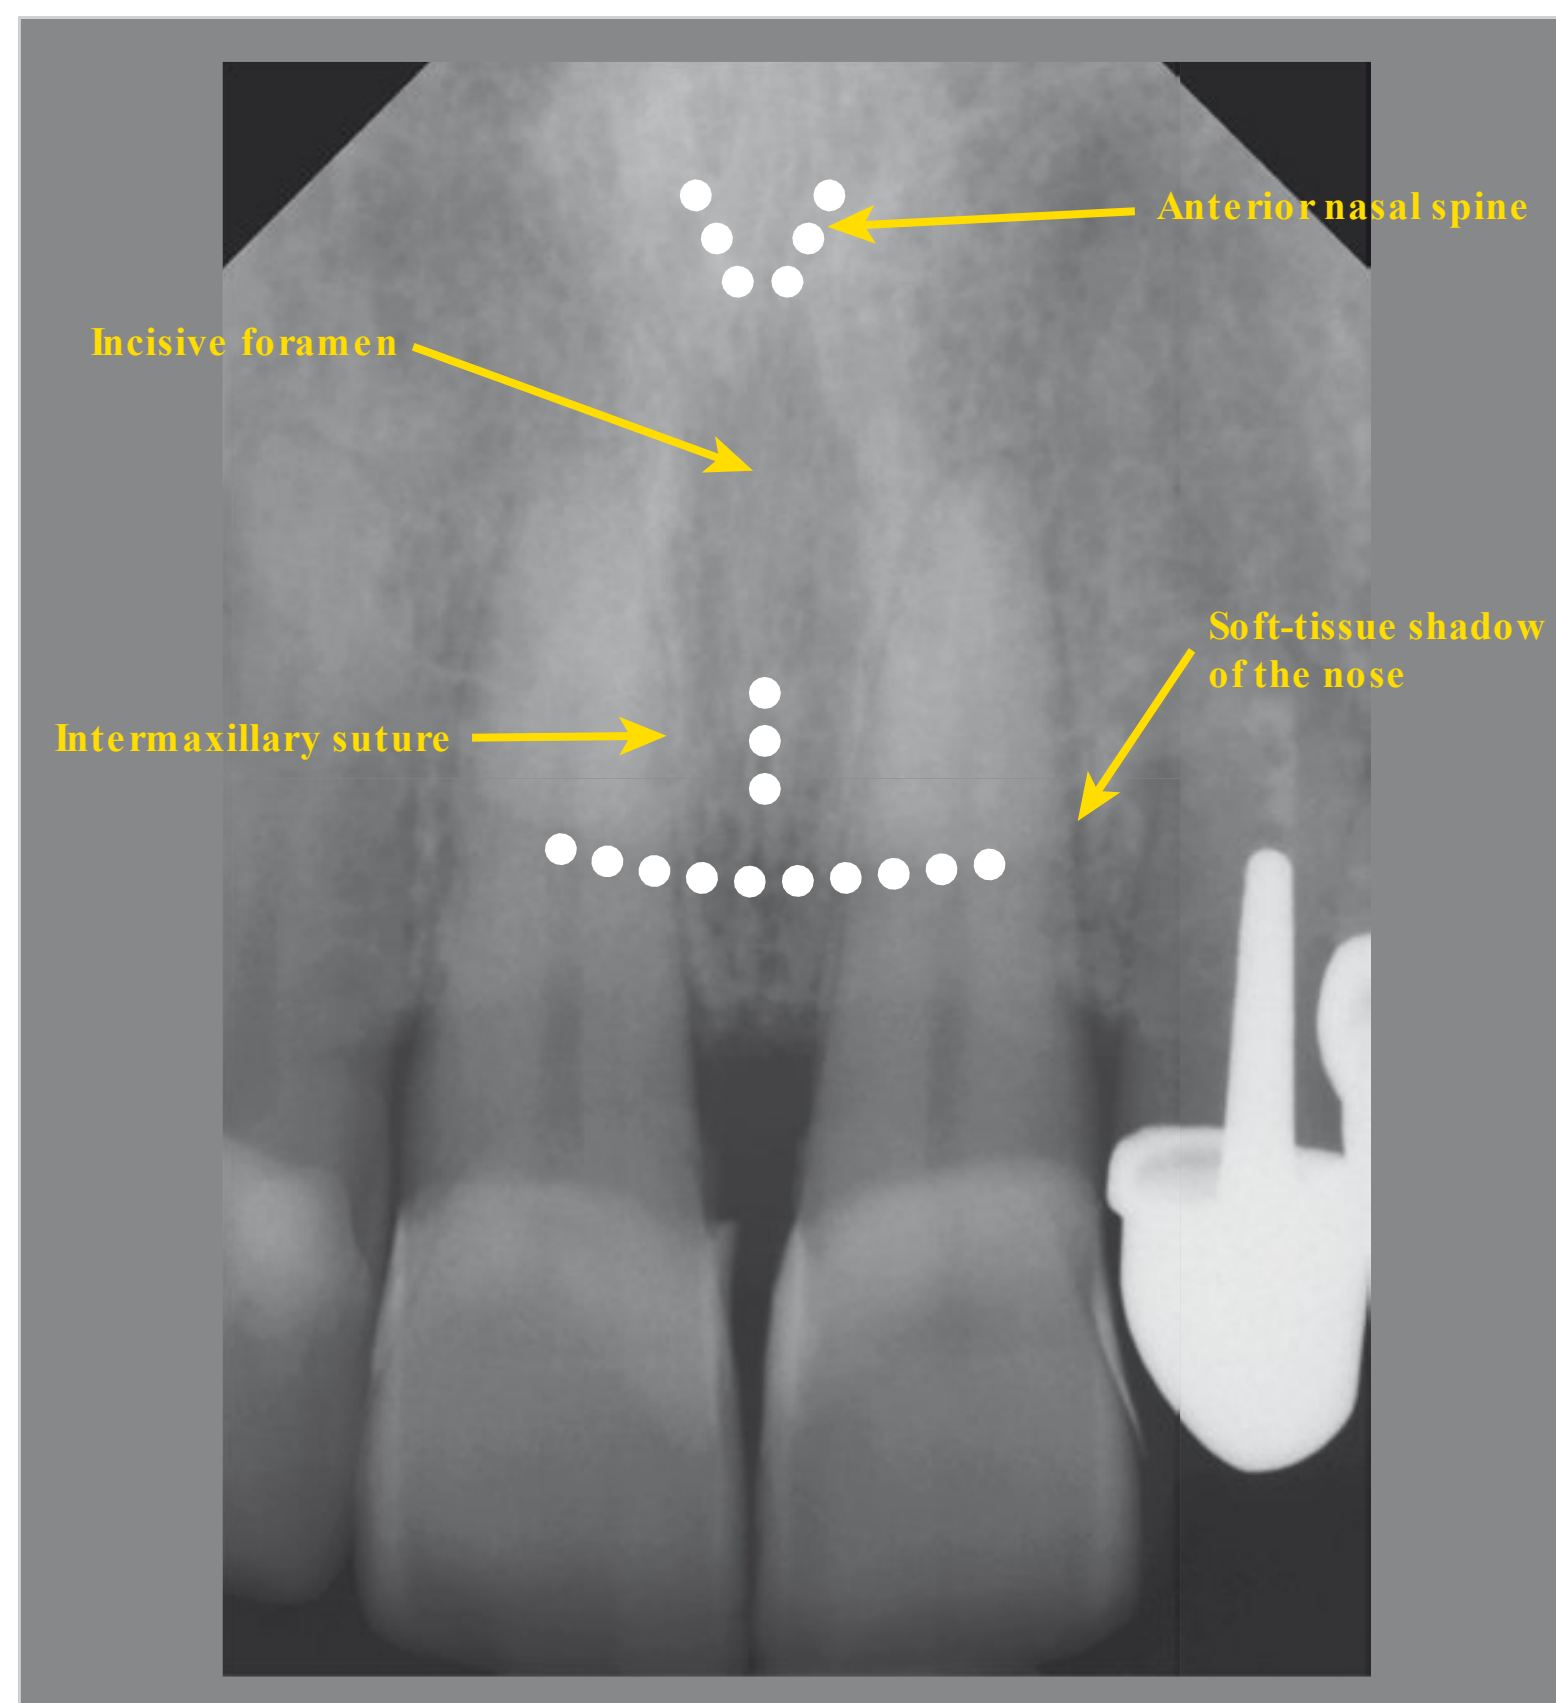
Maxillary anterior region and radiographically relevant (generally identifiable) anatomical structures.
